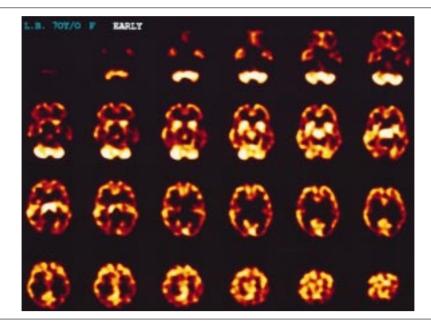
(a) Sequential Tc-99m HMPAO brain SPECT scan sections (approximately 5 mm thick) obtained one week post-stroke. The scans progress from the ventral (top left) to the dorsal part of the brain (bottom right). High tracer uptake were noted in the thalamic regions bilaterally, which when integrated with the abnormalities on the MRI scan were interpreted as the "luxury perfusion" phase of infarction.
